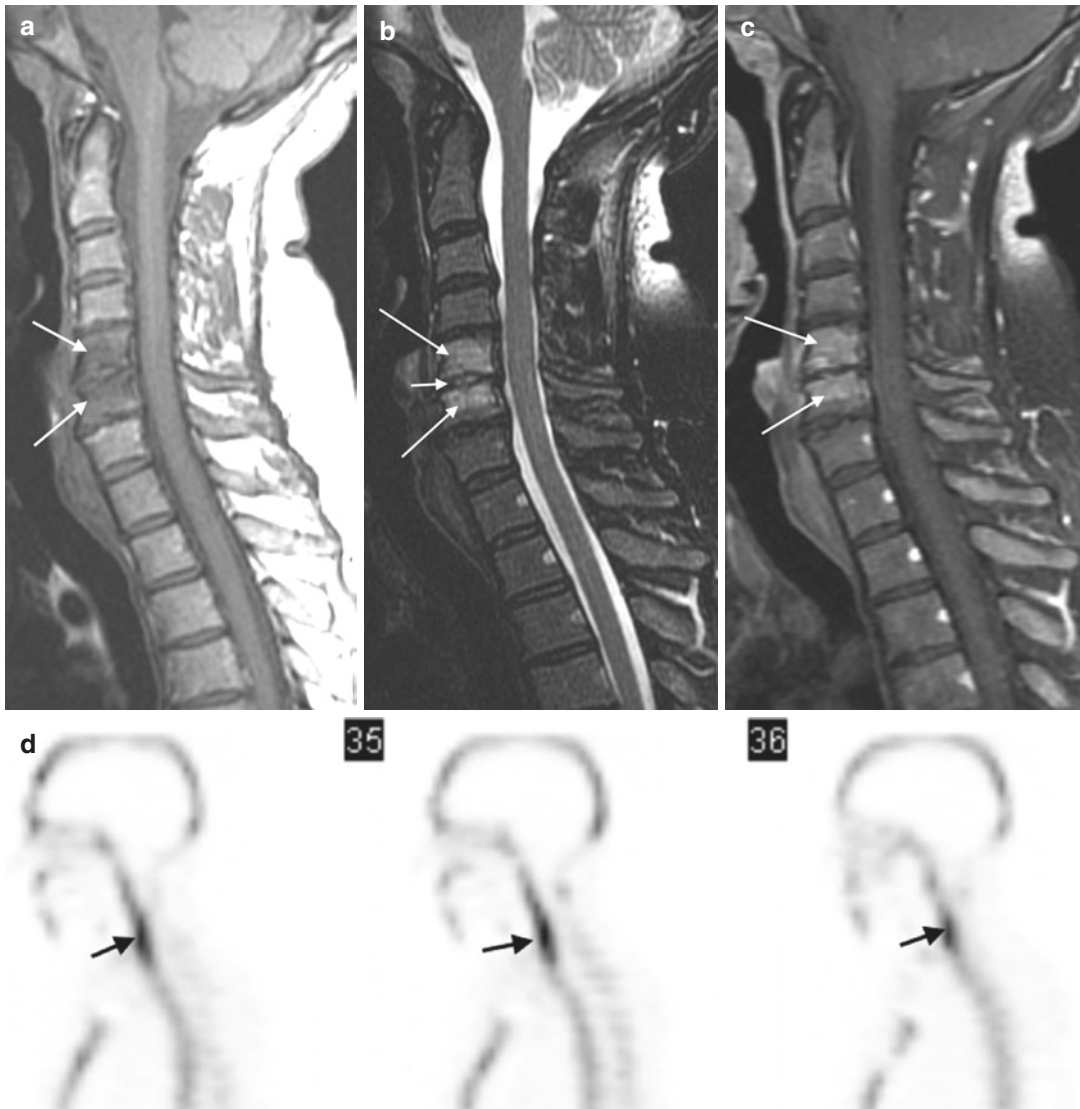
A 44-year-old female with neck pain. T1-weighted sagittal image (a) shows hypointense signal within the C5 and C6 vertebral bodies (arrows). The T2 sagittal image (b) shows hyperintense signal (arrows) within these vertebral bodies and within the intervening disk (small arrow). The fat-suppressed contrast-enhanced T1-weighted sagittal image (c) shows vertebral body
